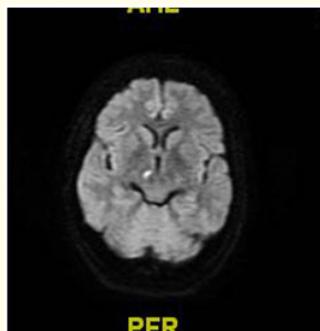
DWI showing restriction.
